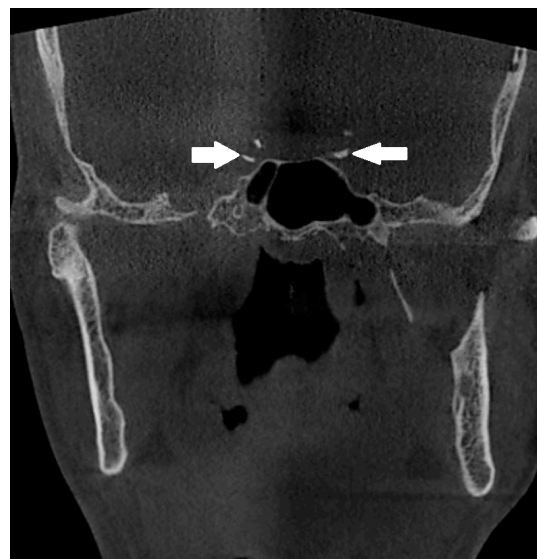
Coronal CBCT image of bilateral IICACs (arrows).
